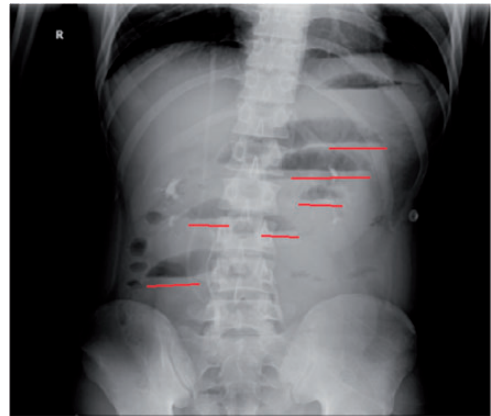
Abdominal plain radiographs showing multiple air-fluid levels (red line).
